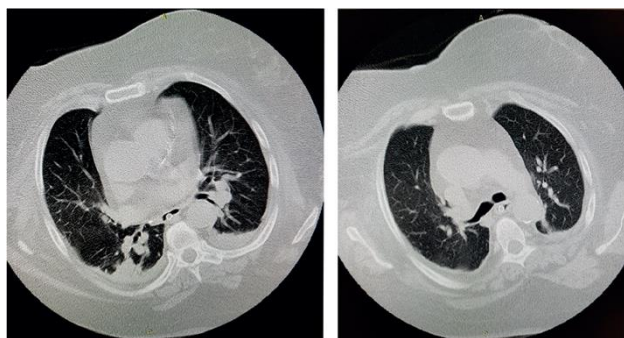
Computed tomography of the chest organs before cessation of veno-venous extracorporeal membrane oxygenation
